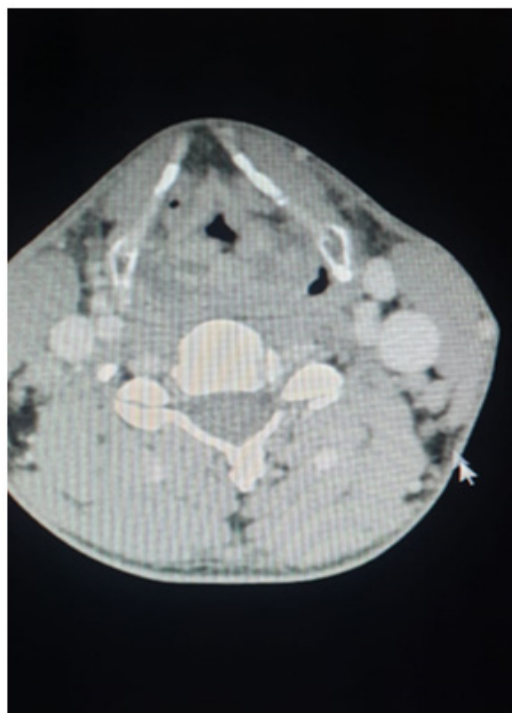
thickening of the vocal cords and aryepiglottic folds and filling of the piriform sinuses with complete cartilage associated with necrotic adenopathies in T2 (Cervico-thoracic CT scan at Cervical stage)
